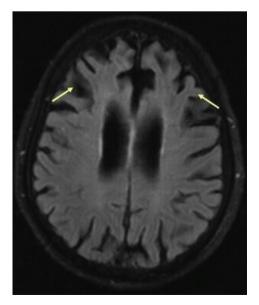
Frontotemporal dementia showing bifrontal atrophy (arrows) on axial FLAIR MR image.
